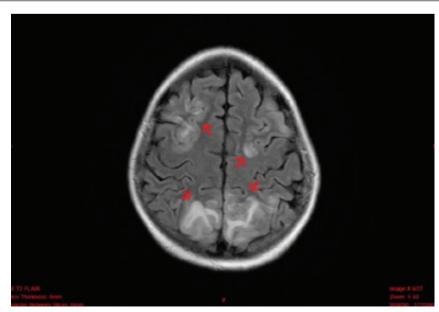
Magnetic resonance imaging, axial slice in T2 and FLAIR sequences. Hyperintense corticosubcortical lesions in the cingulate gyri of parietal and occipital lobes of both hemispheres. Case report 1
